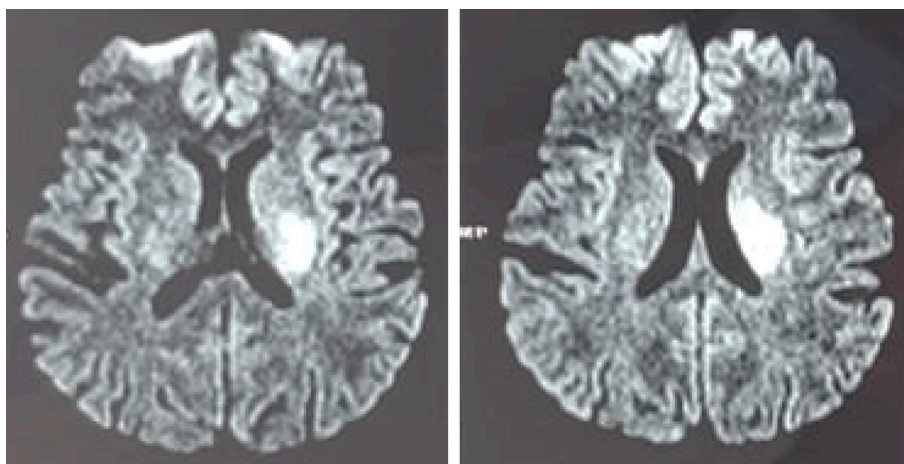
MRI DWI showing restricted area of diffusion in the left corona radiata and internal capsular region.
